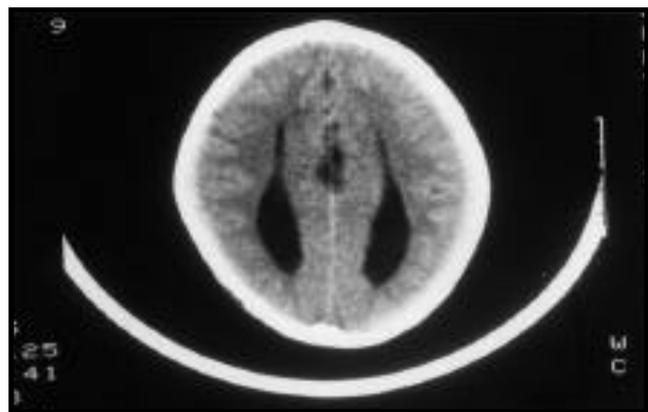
Cranial CT scan showing lateral displacement of the lateral ventricles.
